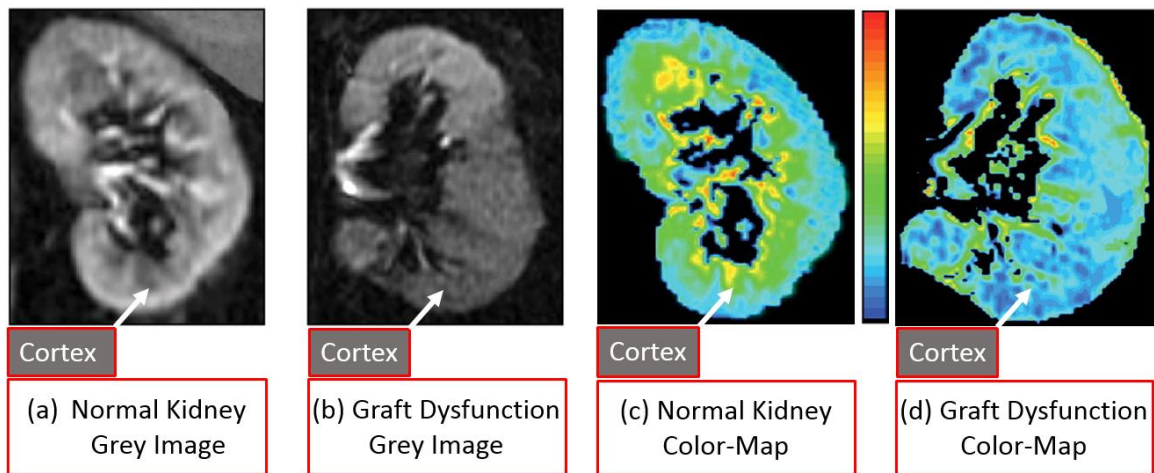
BOLD-MRI grey scale images (a) normal kidney and (b) kidney with graft dysfunction and $R2^*$ color-maps images (c) normal kidney and (d) kidney with graft dysfunction.
